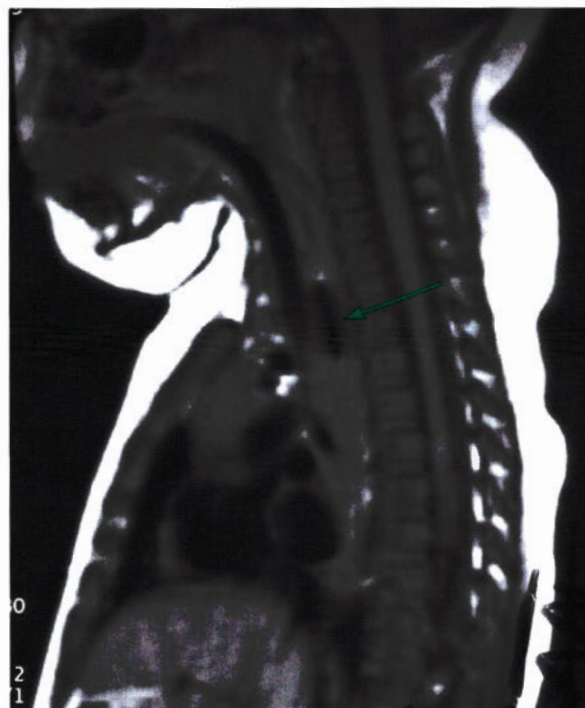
MRI: Foreign Body in the Esophagus
